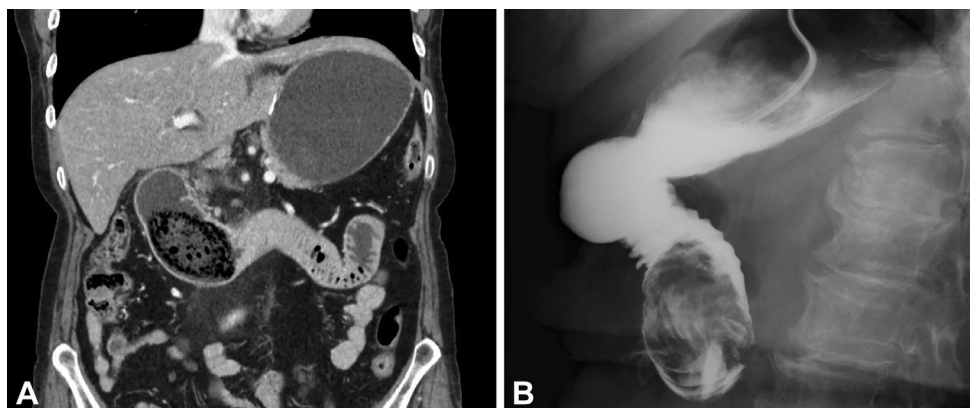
A, CT showed 8-cm defects and duodenal dilation in the more proximal defect. B, Upper GI series shows a giant mass consisting of foreign matter. The mass prevents the contrast medium from flowing beyond it.
